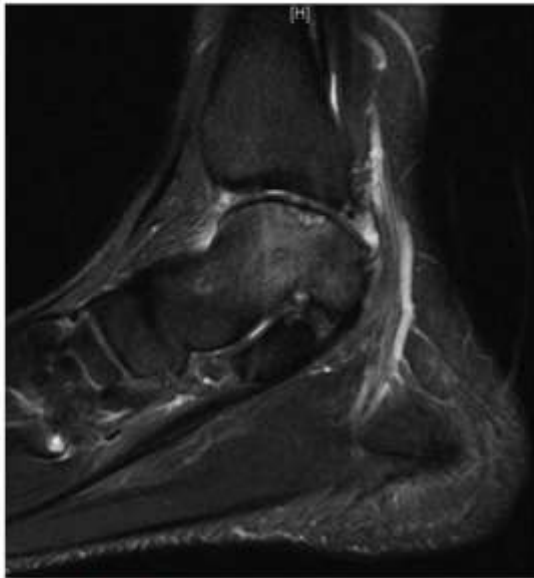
MRI osteochondral defect (OCD) sag.
